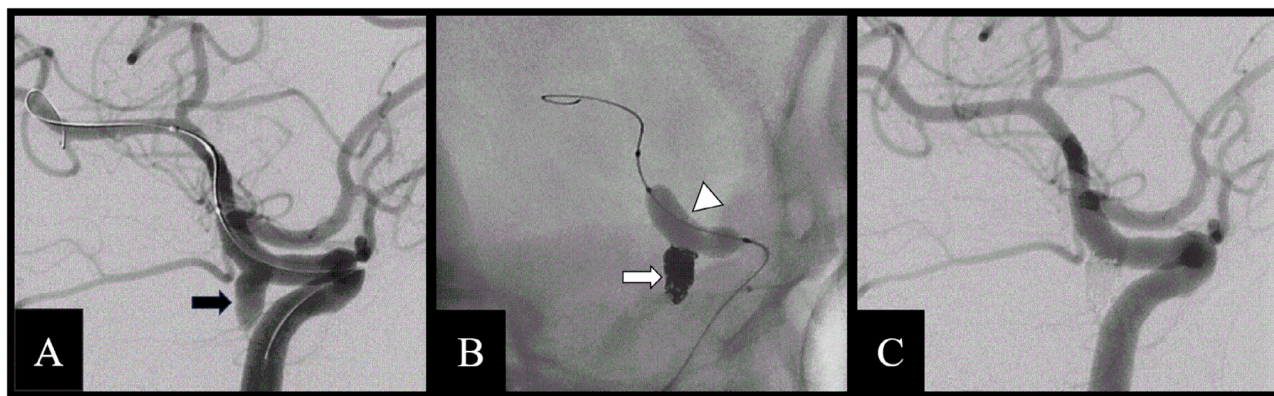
(A) Oblique internal carotid artery angiography showing a wide-neck sacciform aneurysm (black arrow), depending on the terminal segment, (B) Plain radiography showing packing of the aneurysm (white arrow) with Optima coils and an inflated balloon in the parental artery (white arrowhead), and (C) Oblique digital subtraction angiography image showing complete aneurysm occlusion.
